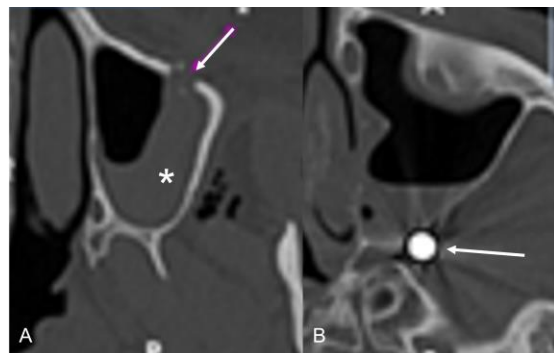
Trajectory of the bullet on CT scan. A. Axial view; arrow: entry point at the anterior wall of the left maxillary sinus. * Blood clot in the left maxillary sinus. B. Axial view; arrow: the bullet is positioned partially in the posterior wall of the left maxillary sinus and in the left pterygopalatine fossa.
